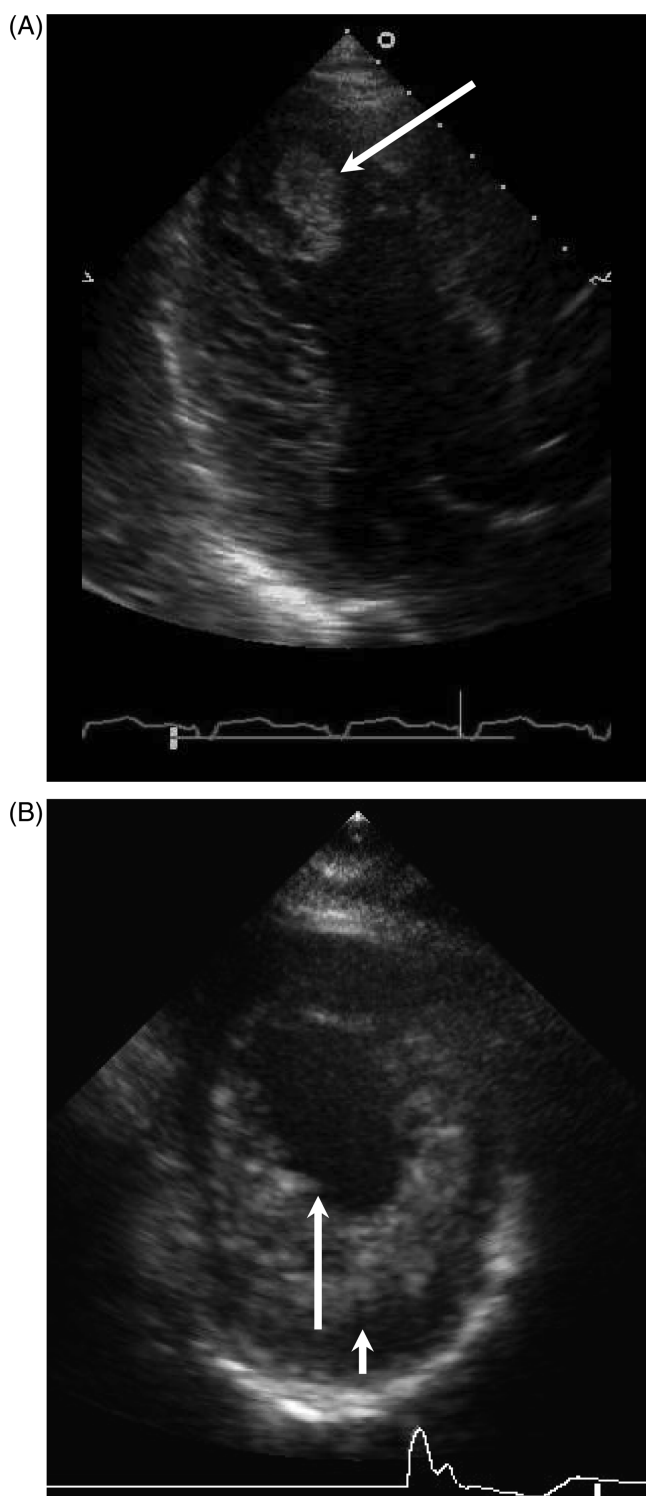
(A) Apical three-chamber and parasternal short-axis view of the index showing prominent thickened apical, lateral, and posterior walls of the left ventricle with loose meshwork of trabeculations; the arrow indicates the left ventricular thrombus; (B) arrows show the non-compacted to compacted ratio in systole is >2 .
